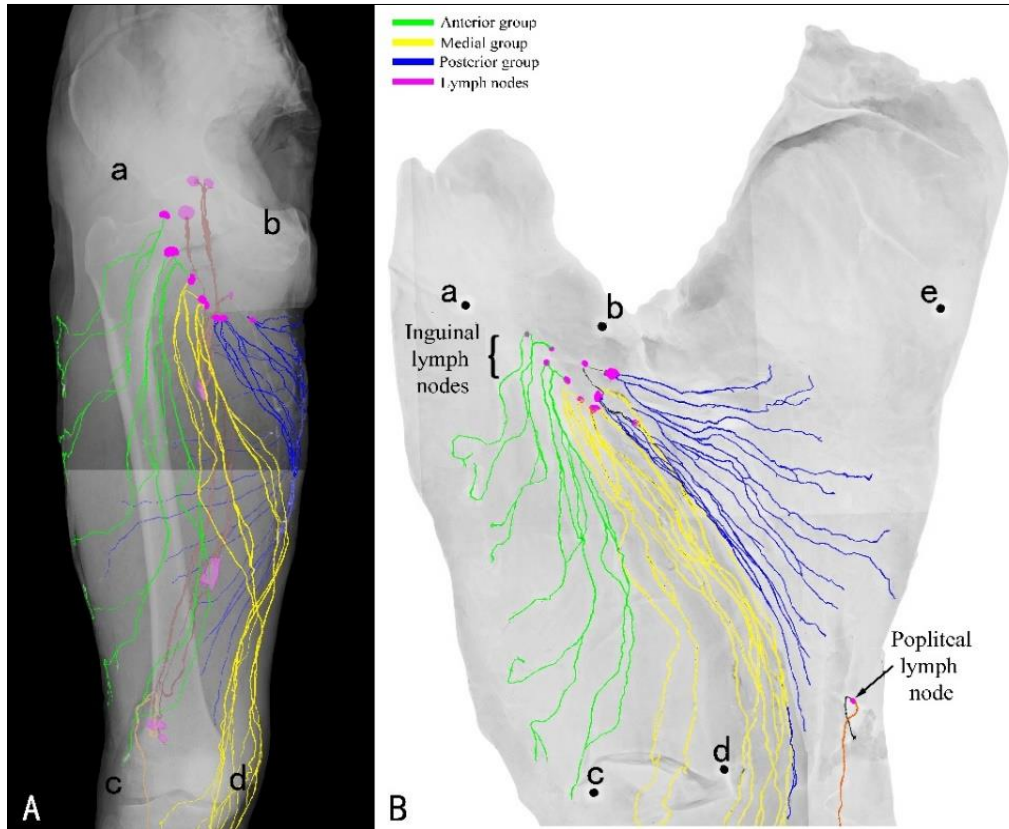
Superficial lymphatic distribution of the human thigh (after perfusion with lead oxide mixture). A: Anteroposterior position of X-ray; B: Flat position of thigh skin. a: Anterosuperior iliac spine; b: Pubic tubercle; c: Lateral epicondyle; d: Medial epicondyle
